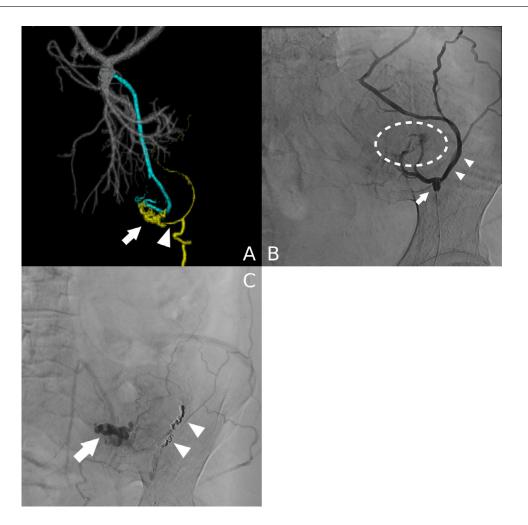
Case 1. (A) Preoperative 3D contrast-enhanced computed tomography image. The inferior mesenteric vein is admitted as a feeding vein to the varix (arrow). A superficial epigastric vein is recognized as a main drainage vein (arrowhead). (B) Balloon-occluded retrograde transvenous venography (B-RTV) using a 3.3-Fr micro balloon catheter at epigastric vein. Collateral draining (arrowheads) veins to the superior epigastric vein are observed. The varix (dotted circle) is not drawn clearly. (C) Retried B-RTV. Varices (arrow) appeared on second B-RTV after coil embolization (arrowheads) of collateral draining veins.
